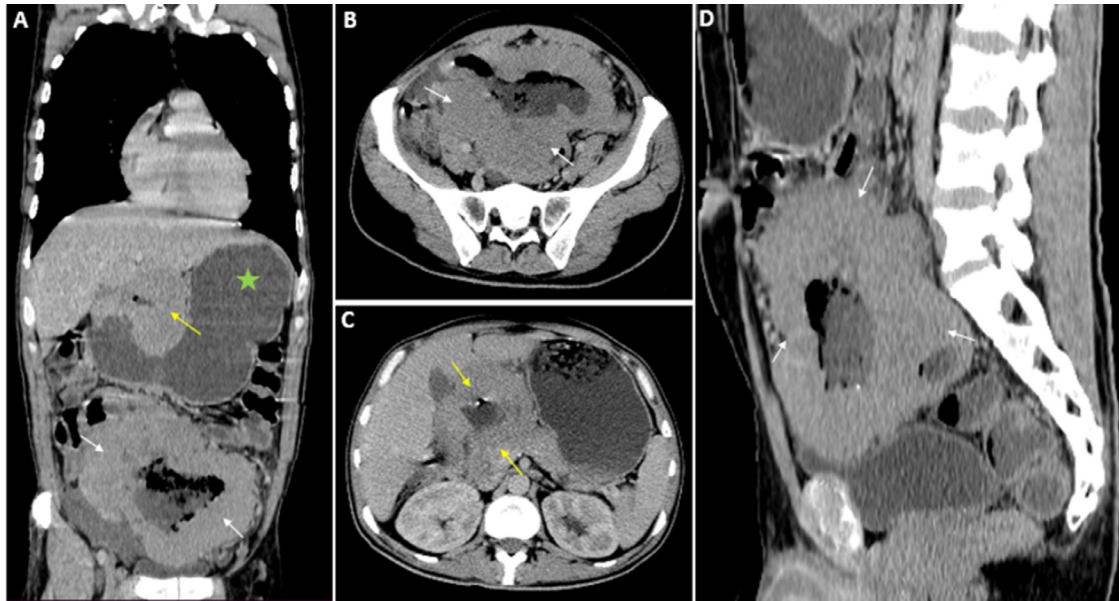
Postcontrast CT of the abdomen and pelvis in coronal, axial and sagittal views, showing a double localization of Burkitt lymphoma of the pyloric and duodenal area (yellow arrows) and the ileal tract (white arrows) presenting as an irregular circumferential and nonstenosing wall thickening, with moderate enhancement after contrast administration and a typical “aneurysmal” aspect.
